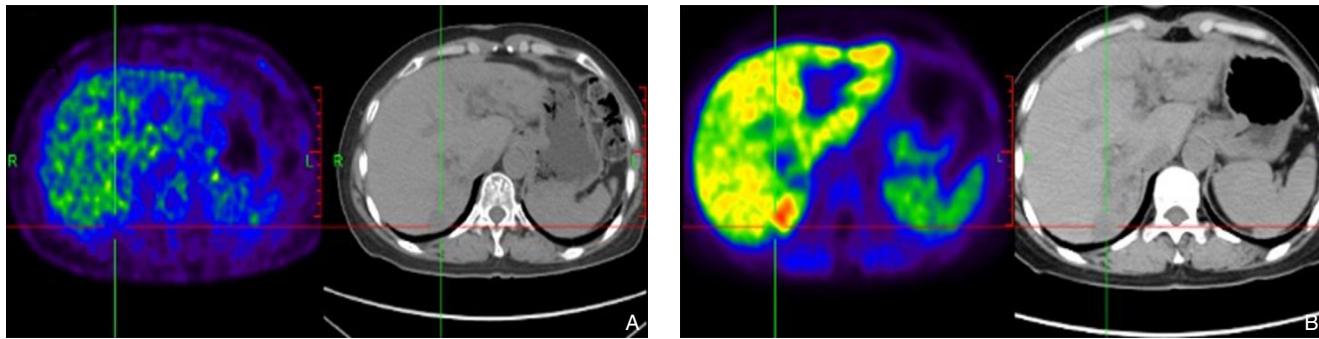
^{18}F -FDG PET/CT A: 低密度的结节, 低糖代谢; B: 胆碱成像病灶摄取量高, 考虑诊断为肝细胞癌
